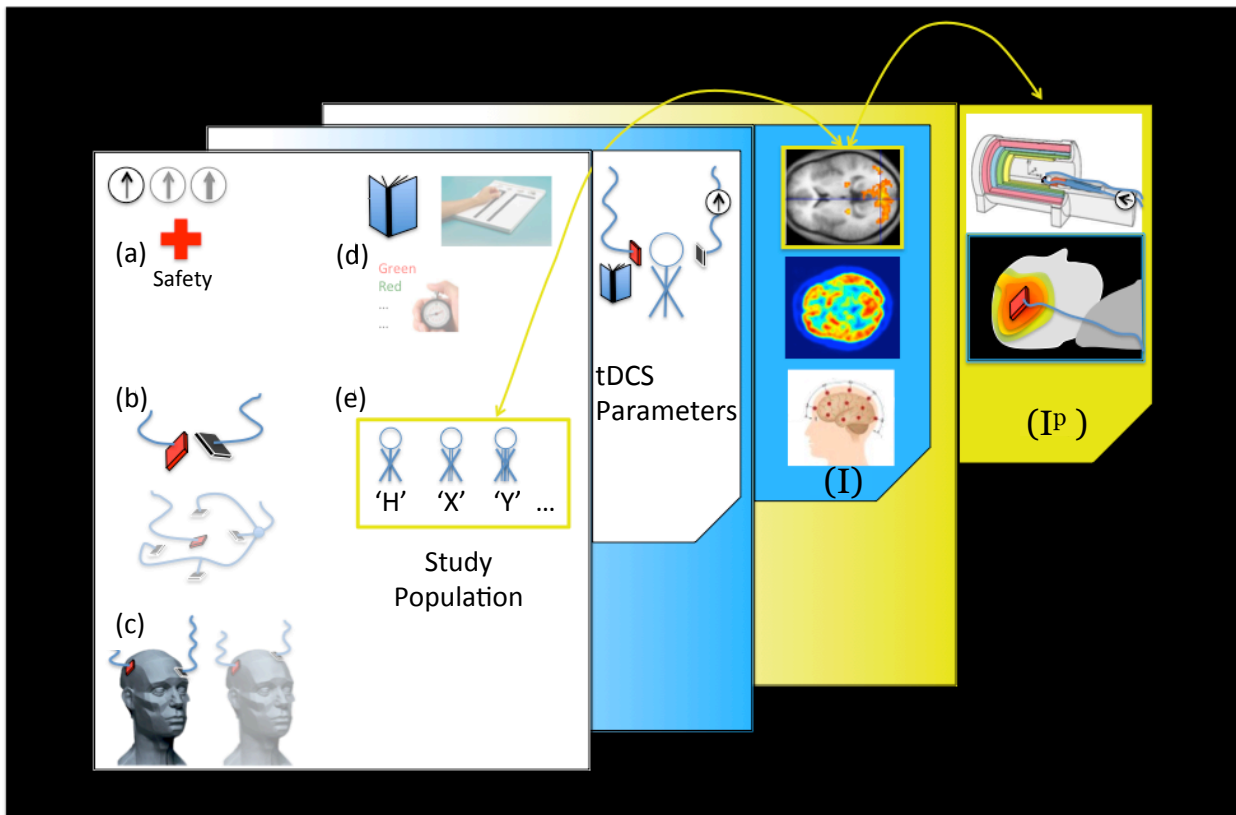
Research in tDCS: WHITE pane shows the parameters in a typical tDCS investigation: (a) Current intensity and duration (limited by safety), (b) electrode arrangements, (c) electrode placement, (d) cognitive paradigms (task/rest), and (e) population. BLUE pane shows imaging techniques used in tDCS research (MRI, PET and EEG are shown). YELLOW pane (I^P) depicts the proposed imaging technique in context: The capability to visualize tDCS currents *in vivo* is expected to complement existing imaging techniques that measure the response of the brain to tDCS.
